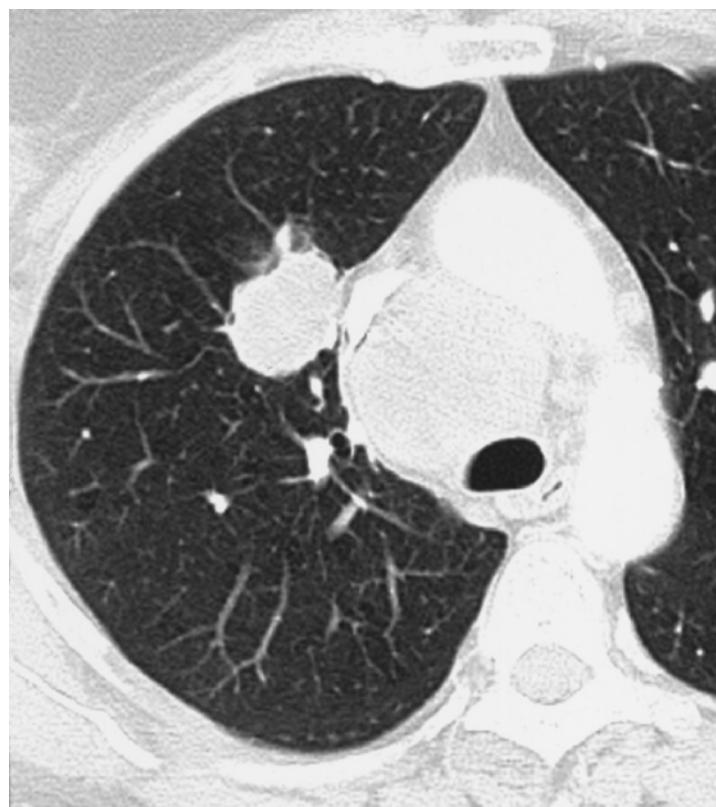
T2 carcinoma. The CT scan shows a bronchial carcinoma measuring over 3 cm in diameter in the central right upper lobe. The tumor is in contact with the mediastinum but has not infiltrated it. Severe ipsilateral and contralateral lymph node metastases (N3) are present; this is stage IIIB disease (radiation therapy and chemotherapy).
